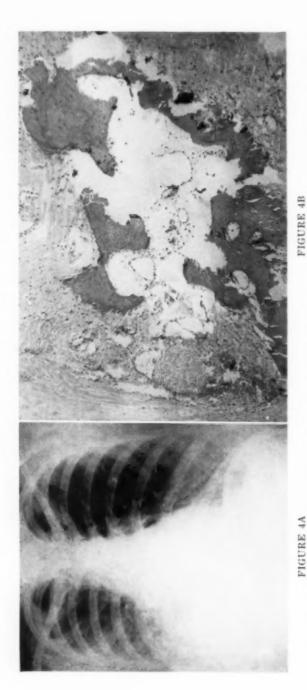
(Case 4): (A) Chest roentgenogram July 18, 1955 showing right pleural thickening, enlargement of a lymph node about the bronchus intermedius and collapse of the right middle lobe. (B) Osseous metaplasia of mediastinal fibrous tissue obtained at second thoracotomy.
